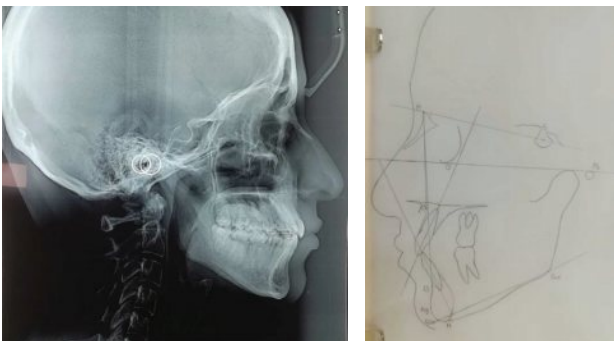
Follow up cephalometric radiograph
